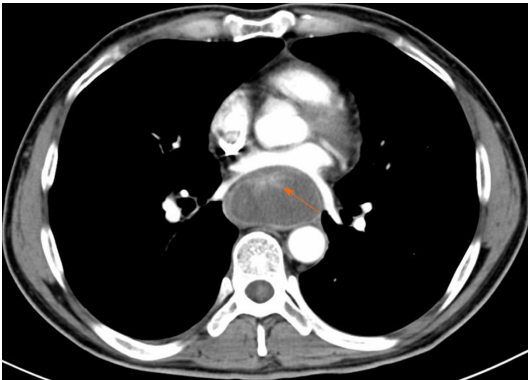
Computed tomography showing a prominently enhanced anterior area of the giant mass beside the esophageal wall (orange arrow), and the maximum sectional area was about 5.6 cm × 3.5 cm.
